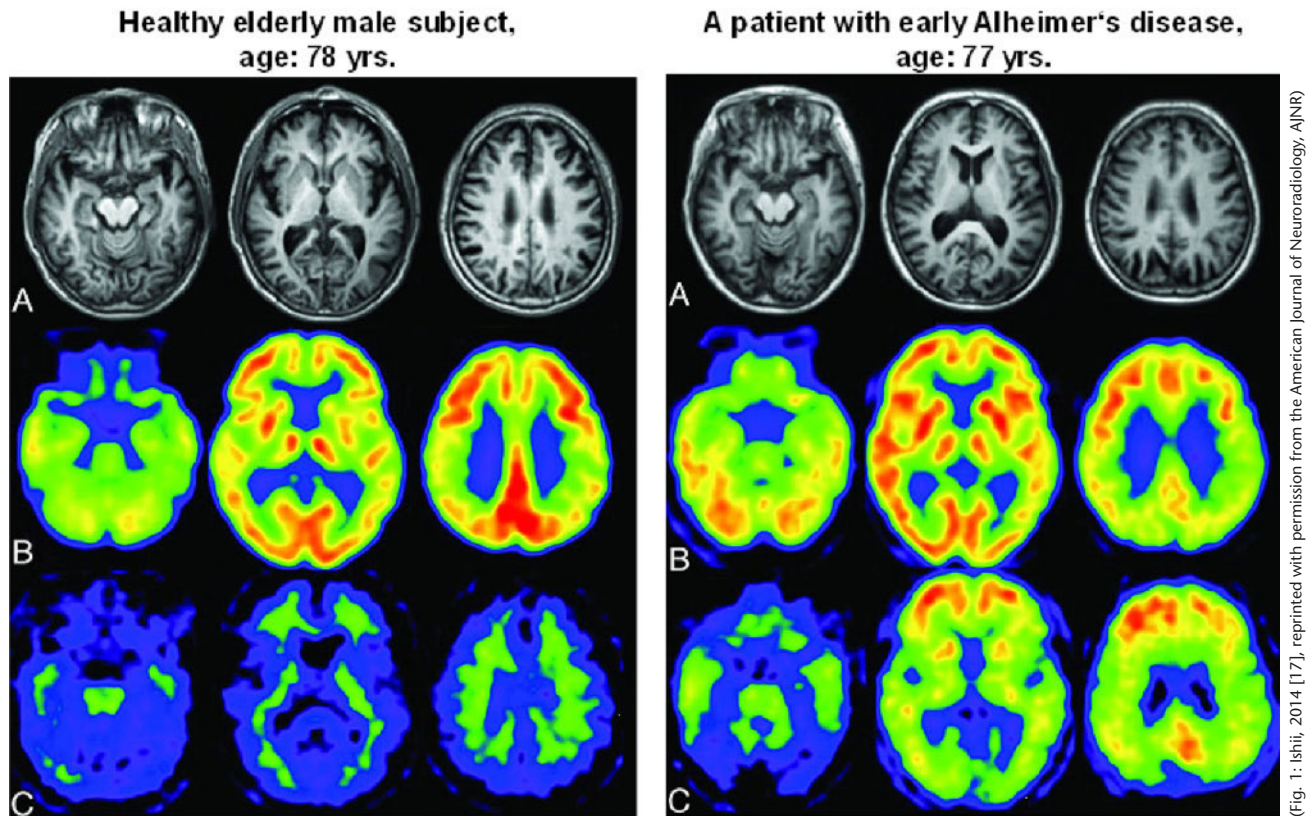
Diagnosis of Alzheimer's disease by non-invasive imaging. Left: Healthy elderly male subject, age: 78 years, Mini-Mental State Examination score: 30. (A) Note the slightly enlarged right inferior horn of the lateral ventricle on the T1-weighted MR image. (B) Note that the regional glucose metabolism is not reduced on the FDG-PET images. Note that glucose metabolism in the posterior cingulate is much larger than that in other regions. (C) PiB-PET reveals nonspecific accumulation in the white matter but no PiB accumulation in the gray matter. The amyloid deposit is negative. Right: Patient with early Alzheimer's disease, age: 77 years, Mini-Mental State Examination score: 25. (A) Note the slight atrophy of the right hippocampus. (B) FDG-PET reveals diminished glucose metabolism in the bilateral parietotemporal association cortices and posterior cingulate gyri and precuneus. (C) PiB accumulation is seen in the cerebral cortices except for the occipital and medial temporal regions. High PiB accumulation is present in the medial parietal and frontal regions, indicative of positive amyloid deposit [17].
